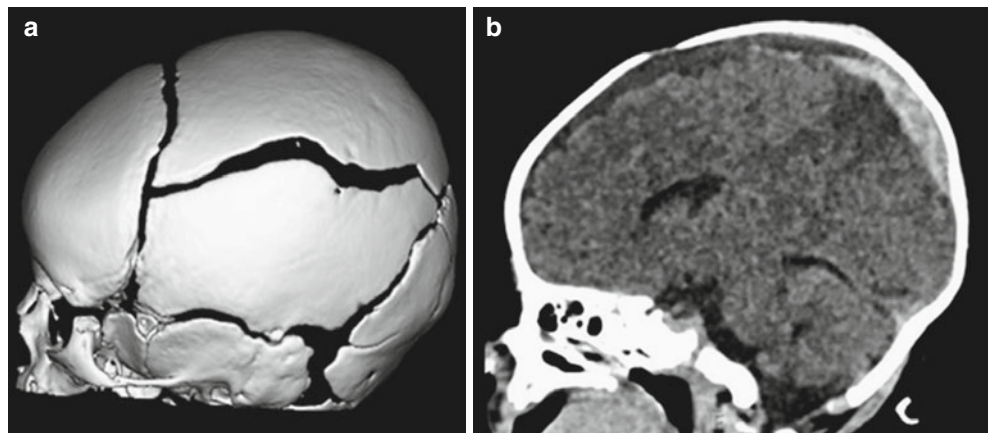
3D CT image (a) shows a linear mild diastatic non-displaced fracture through the left parietal bone extending from the coronal suture to the lambdoid suture. Sagittal 2D CT image (b) reveals a hyperdense subdural hematoma in the left parietal region. Moreover, cortical contusion with subcortical edema is noted in the underlying left parietal lobe
